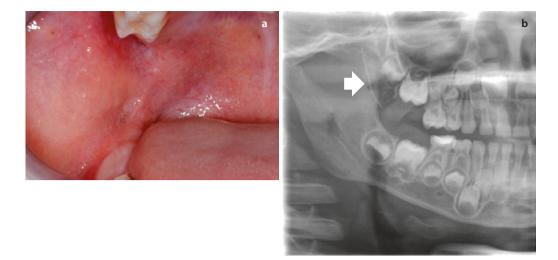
A juvenile patient with a broken needle. Half an hour after the accident, the injection location can no longer be observed in the oral cavity a. The panoramic X-ray shows a vertical broken needle of type for infiltration anaesthesia. The dentist intended to administer mandibular block anaesthesia b
